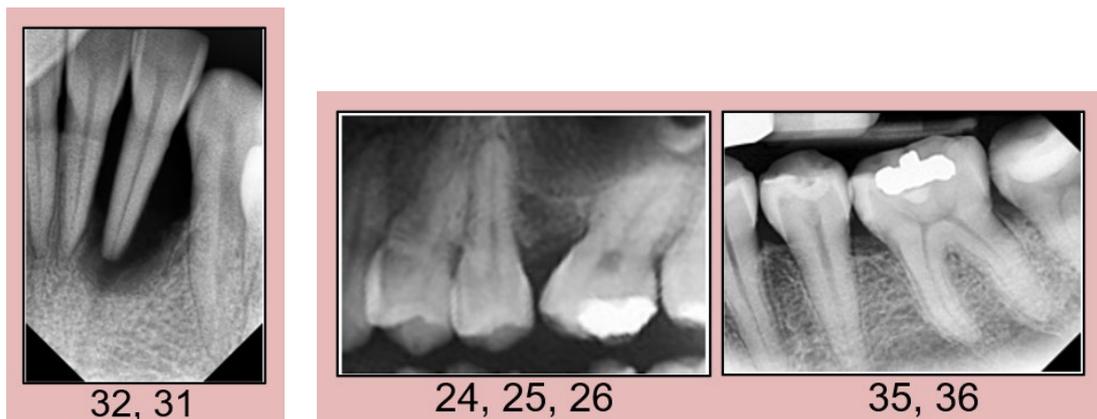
Intraoral periapical radiograph of Case 3.
